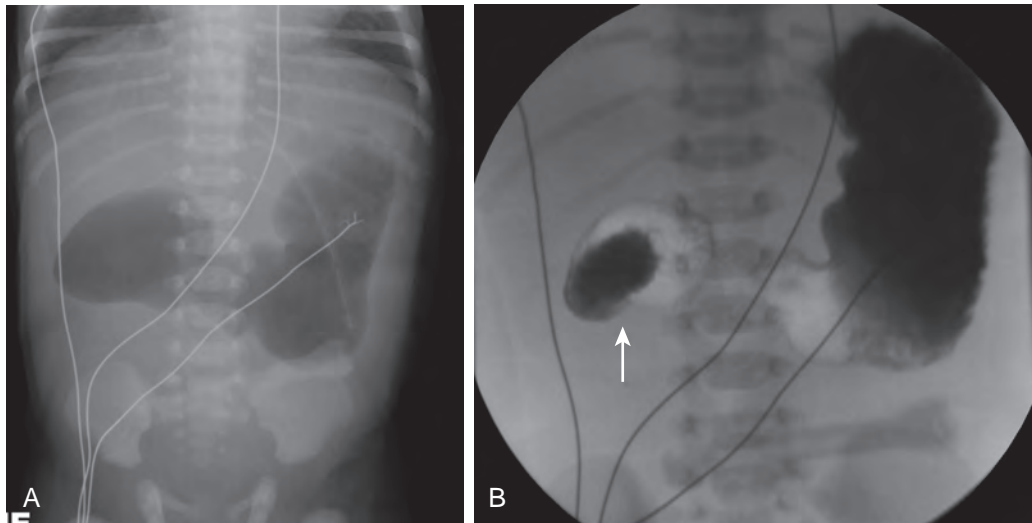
Duodenal atresia. A. Abdominal radiograph of a newborn infant shows the classic double bubble with dilated, air-filled stomach and duodenum. B. Upper gastrointestinal examination shows the duodenum dilated out of proportion to the stomach, a characteristic appearance for duodenal atresia, and complete obstruction of passage of contrast material beyond the level of the atretic segment (arrow).
